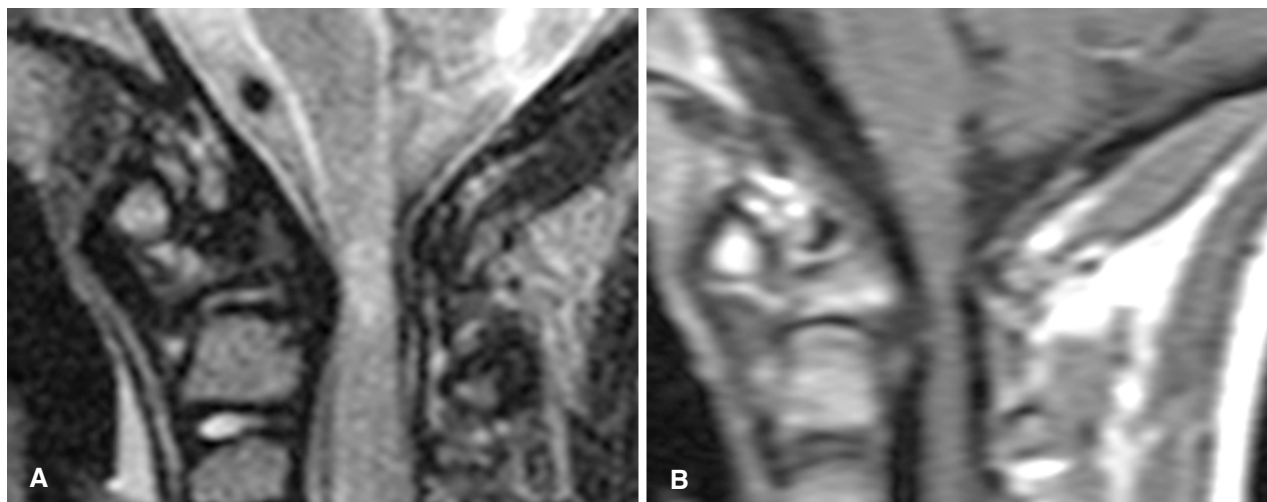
MR images: A T2-weighted image of the cervical spine shows os odontoideum, retrodental soft tissue mass narrowing down the spinal canal at C1-2, and a hyperintense spinal cord signal. B A gadolinium-enhanced T1-weighted MR image did not show any abnormal enhancement.
